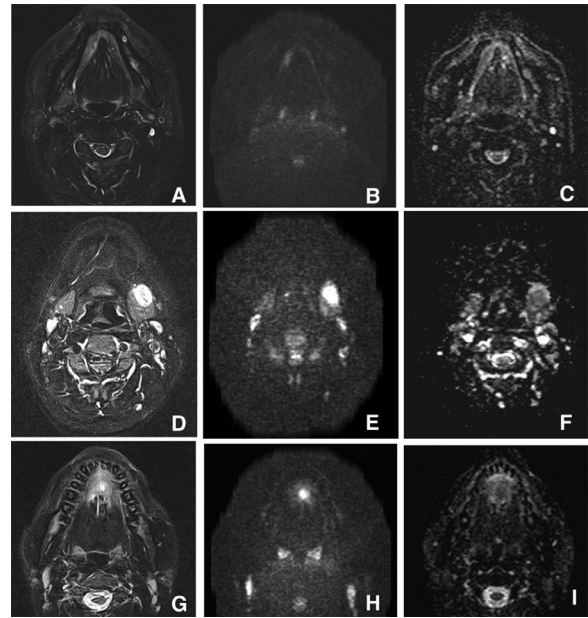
The MRI findings of a squamous cell carcinoma (A, B, C), an adenoid cystic carcinoma (D, E, F), and inflammation (G, H, I) as examples of lesions with cystic components on STIR (A, D, G), DWI (B, E, H), and the ADC map (C, F, I). The ADC map for the squamous cell carcinoma (C) showed an ADC value of $0.92 \times 10^{-3} \text{ mm}^2/\text{s}$. The ADC map of the adenoid cystic carcinoma (F) had an ADC value of $1.10 \times 10^{-3} \text{ mm}^2/\text{s}$. The ADC map of the inflammatory lesion (I) had an ADC value of $1.52 \times 10^{-3} \text{ mm}^2/\text{s}$. The ADC values for these lesions were significantly lower than those of ranulas in this study. *ADC*, apparent diffusion coefficient; *DWI*, diffusion-weighted imaging; *MRI*, magnetic resonance imaging; *STIR*, short-T1 inversion recovery.
